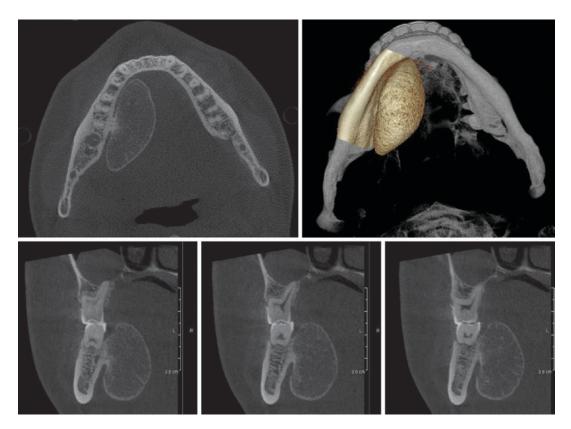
Peripheral osteoma. CBCT axial and cross-sectional images reveal a unilocular well-defined calcified hyperdense peduncled lesion which is attached to mandibular lingual cortical plate
